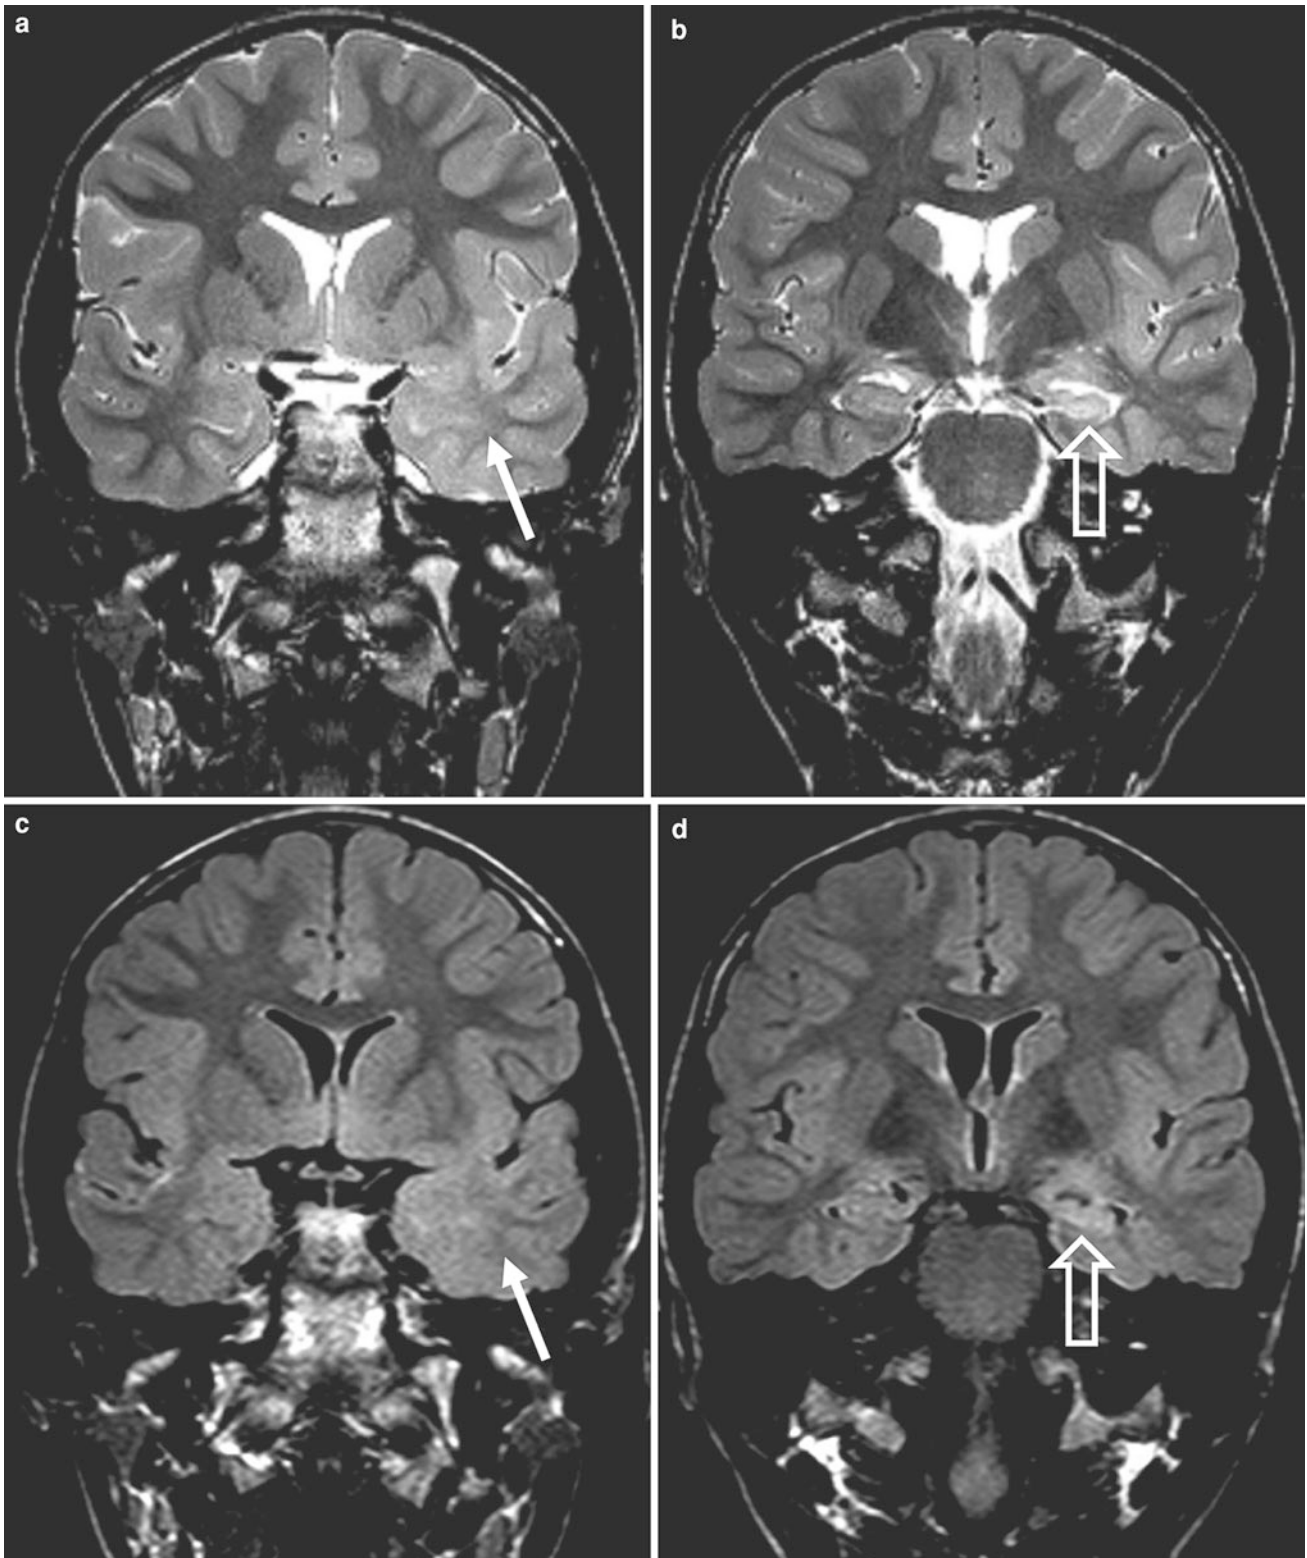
A 21 year old man with complex partial seizures since the age of 18 underwent left-side selective amygdalohippocampectomy. On MRI, the left hippocampus is of normal size (a–c: 2 mm thick T2-weighted fast spin echo images, d, e: 3 mm thick FLAIR fast spin
